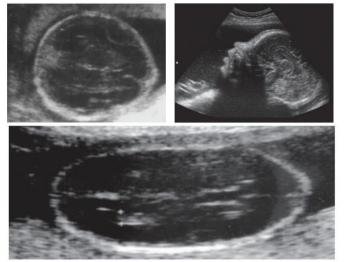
Images (A) and (B) show images of decreased ossification of the calvaria bone, resulting in well-visualized brain tissue (when compared to normal prenatal ultrasound). Image (C) on pressing with the transducer shows the deformity or compressed shape of the calvaria (Kartika & Suadiatmika, 2018)
